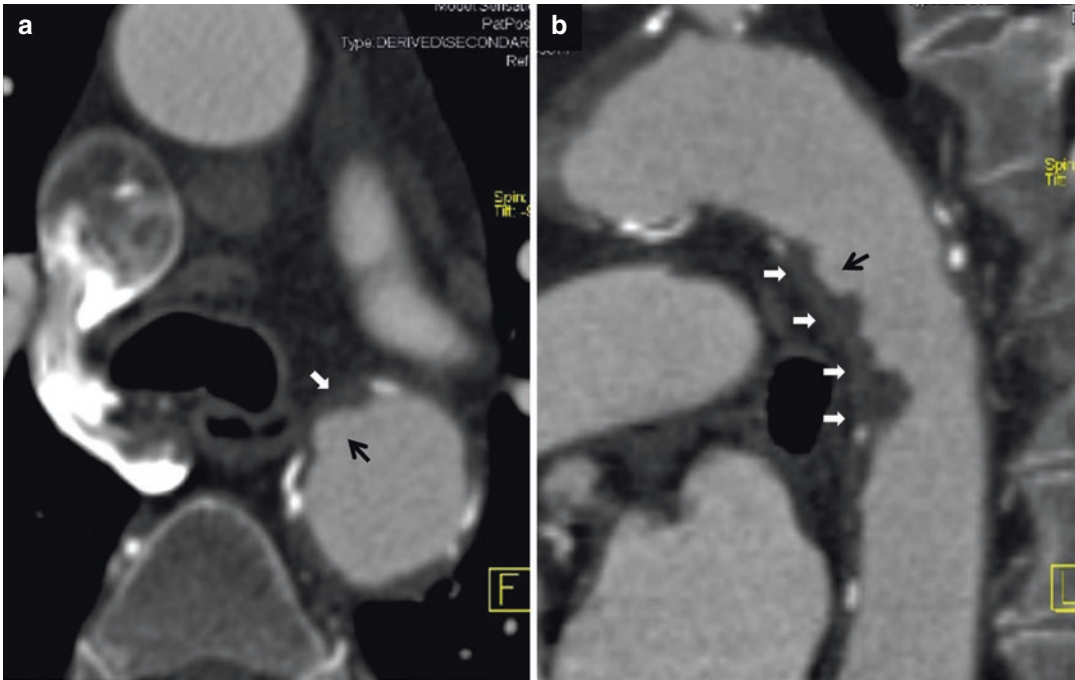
(a) Axial CT scan and (b) oblique MPR show ulcerative (*black arrows*) plaques (*white arrows*)
